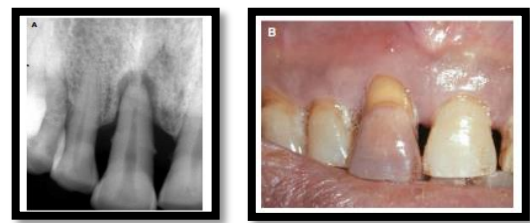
True combined endodontics and periodontal disease. (A) X-rays showing bone loss of two-thirds of the roots, as well as stones and radiation permeability around the apex. (B) Laboratory examination revealed a coronal color change and pus oozing from the gingival sulcus. The pulp sensitivity test was negative
